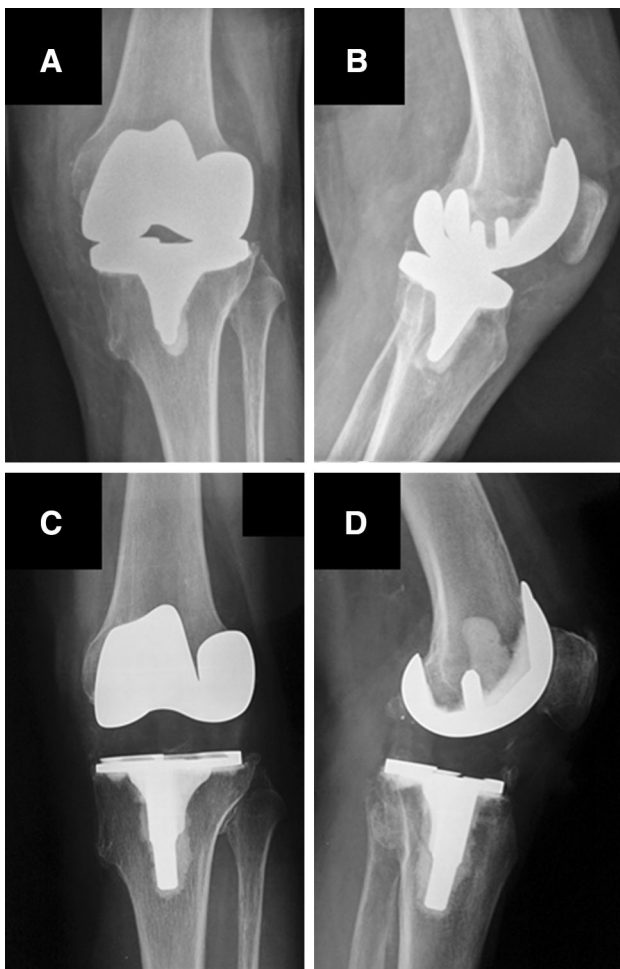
Plain radiographs of the right knee. a Pre-revision anteroposterior view, b pre-revision lateral view, c anteroposterior view 3 years after revision TKA, d lateral view 3 years after revision TKA
